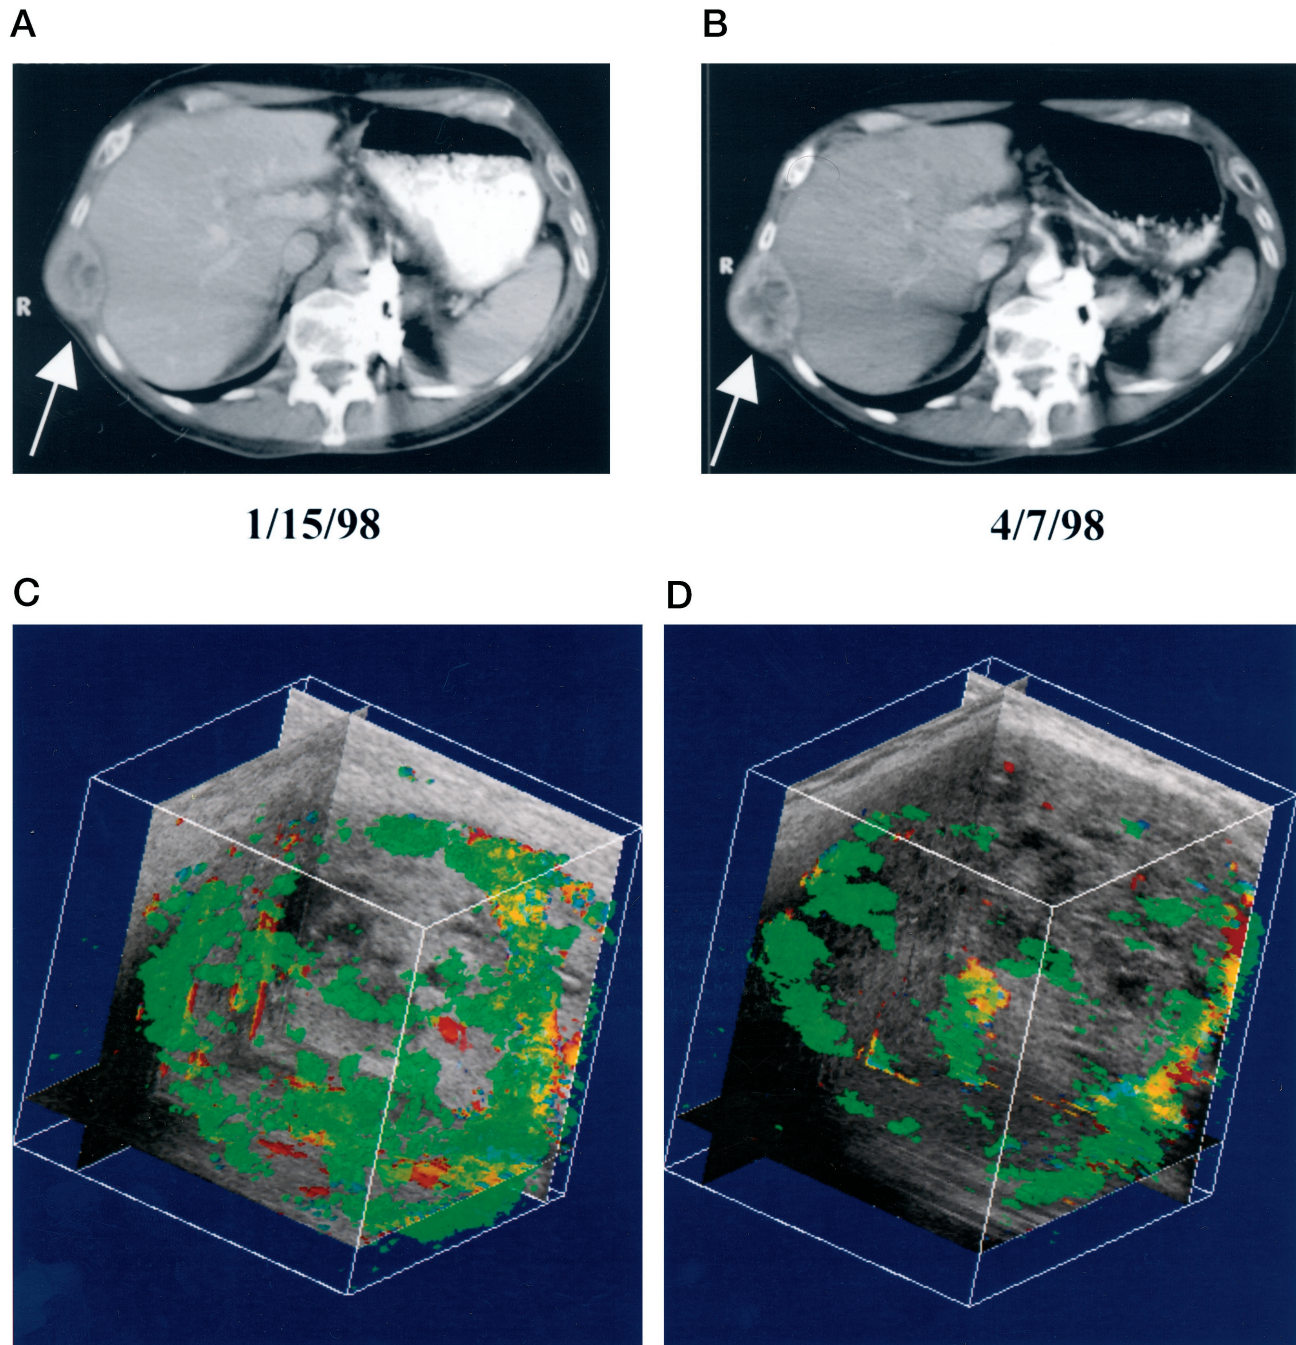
Evaluation of antiangiogenic response to copper deficiency. CAT scans of the chest of a 59-year-old male with metastatic renal cell carcinoma shortly after achievement of target Cp (*A*) and 8 weeks later (*B*) are shown. Comparable frequency-shift color Doppler image volumes from the superficial renal cell carcinoma rib metastasis were evaluated at the same time points (*C* and *D*). Three-dimensional rendering of the vascularity is shown in *green* superimposed on three orthogonal image planes extracted from the reconstructed grayscale volume. The back plane shown exemplifies one of the frequency-shift color Doppler image planes acquired during the patient scan. Vascularity at initiation of TM therapy (*C*) is markedly greater than that seen 8 weeks later (*D*). Quantitatively, color pixel density is 4.4 times greater in the tumor volume scanned at the first time point; the mean flow velocities are equivalent at both times.
